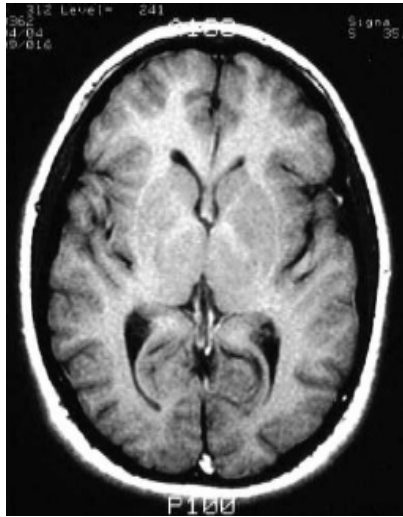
Axial MRI's (T1) showing a more dorsal level of the temporal lobe as compared to figure . (From R, Swenson, Dartmouth Medical School)
